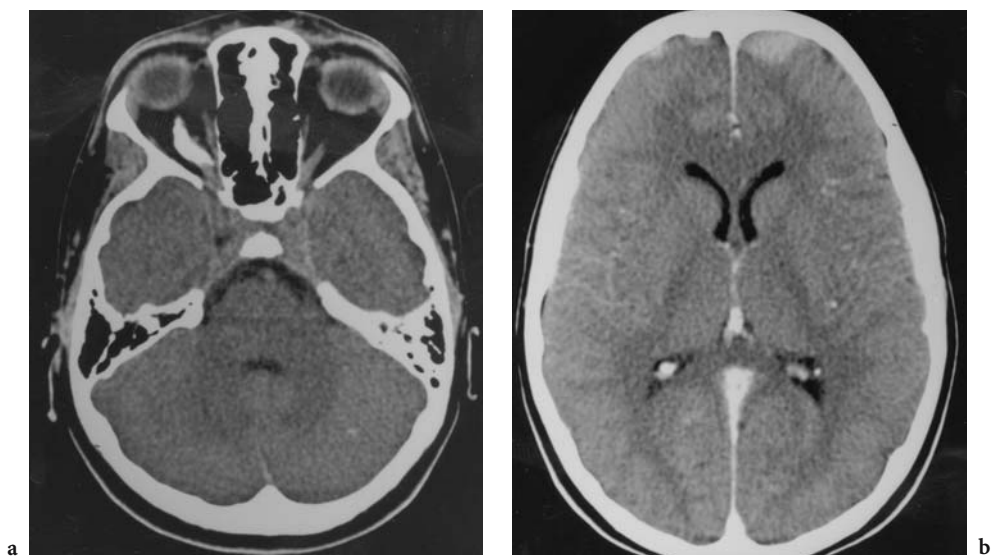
a Axial plain CT, b axial CT following administration of contrast medium in a 14-year-old patient prompted by new onset of diplopia. Plain CT reveals calcifying right optic nerve sheath meningioma. Following contrast: left frontal meningioma. Bilateral acoustic neuromas not shown
